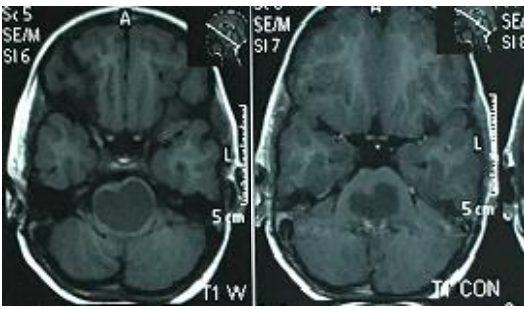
Preop. Brain MRI T1 without & with contrast
